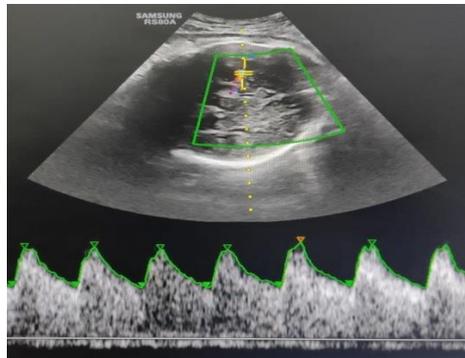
MCA Doppler showing brain sparing effect.
